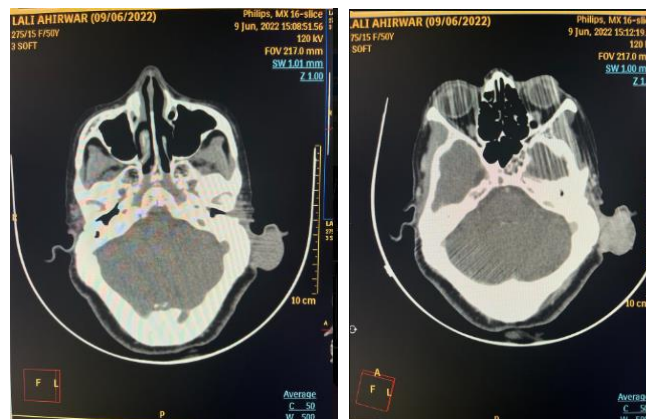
Pre and post contrast axial CT scan images shows a lobulated soft tissue density lesion with attenuation similar to adjacent muscle noted in subcutaneous plane in left posterior auricular region with involvement of overlying skin with significant post contrast enhancement.
